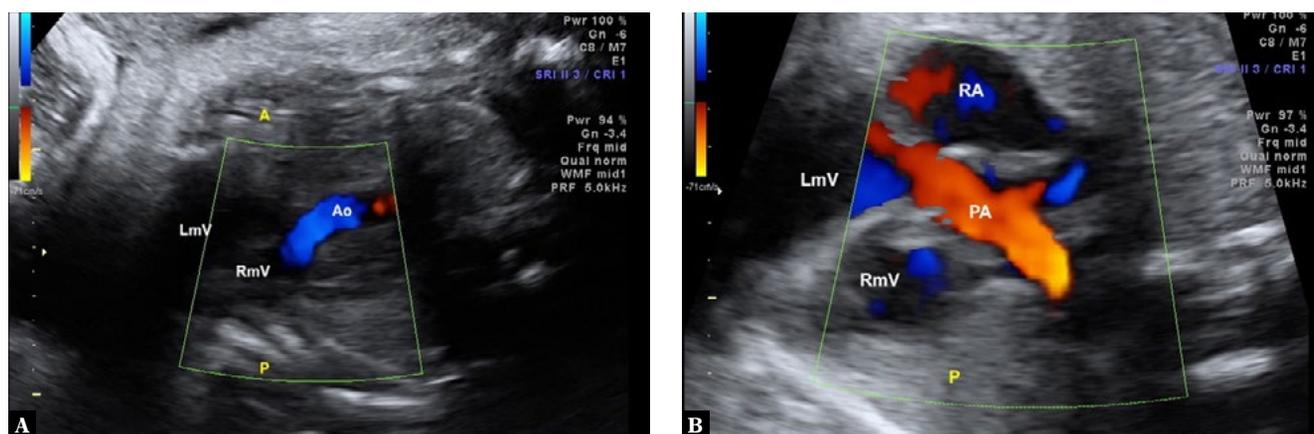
Fetal echocardiography at 37 weeks of gestation showing the ventricular outflow tracts: A. the aorta artery arising from the right morphologically ventricle (left-sided ventricle) and B. the pulmonary artery arising from the left-morphologically ventricle (right-sided ventricle). Ao – aorta; PA – pulmonary artery; RA – right atrium; RmV – right morphological ventricle; LmV – left morphological ventricle; A – anterior; P – posterior
